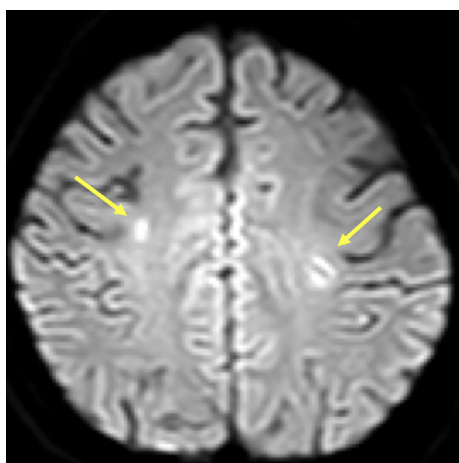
Findings of brain magnetic resonance imaging (diffusion-weighted imaging) indicate multiple thromboembolisms (yellow arrows).
